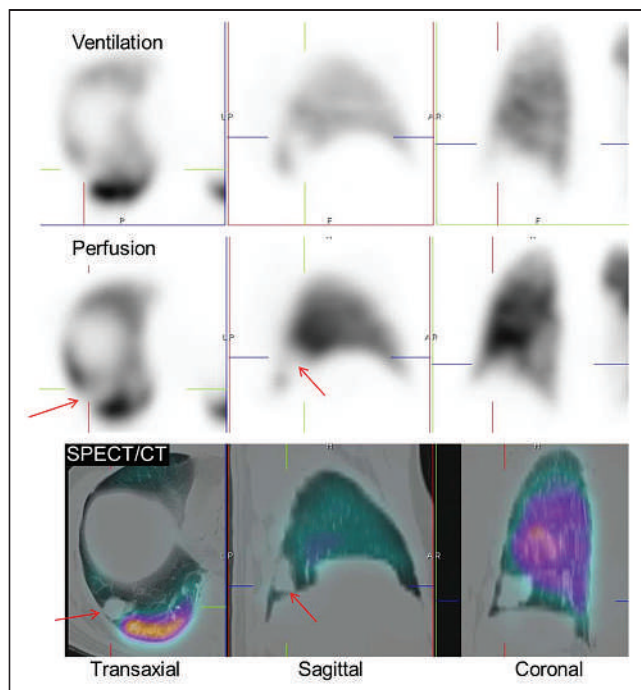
Fusion of SPECT and low-dose CT showing opacity (arrows) on CT corresponding to perfusion defect producing matching defect consistent with lung metastases. (Reprinted from (5).)
